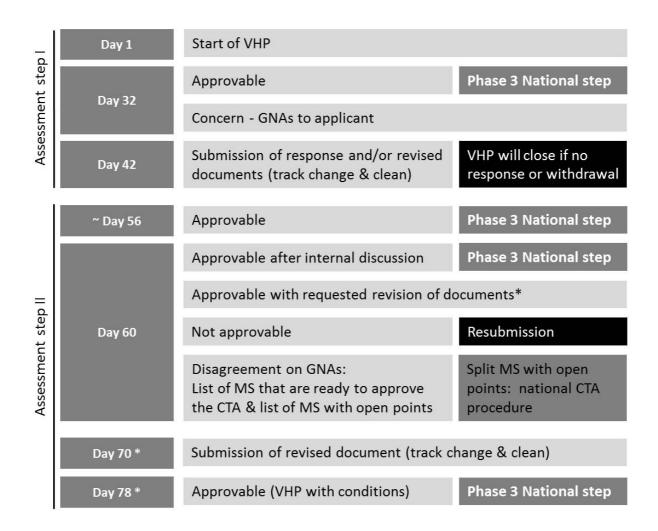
Phase 2 - VHP CTA Assessment Step (modified according to [5])
